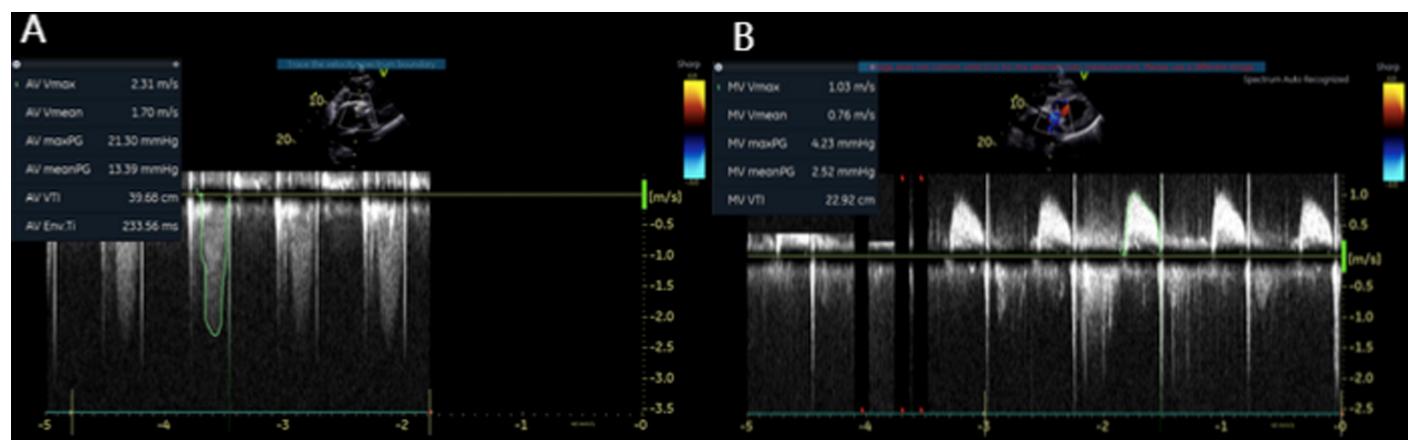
Postoperative transthoracic echocardiographic findings.
